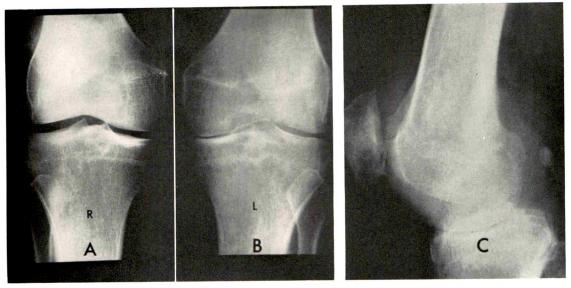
Case I. (A and B) Plain roentgenograms of both knees and (C) a lateral view of the involved left knee.
